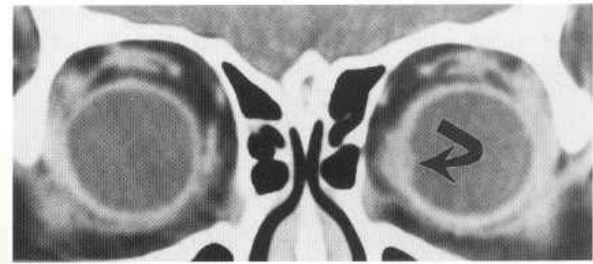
Choroidal melanoma. Contrast-enhanced coronal CT image demonstrates enhancing lesion of the medial retina of the left eye with trans-scleral invasion (arrow). (Case courtesy of Orlando Ortiz, M.D.)
